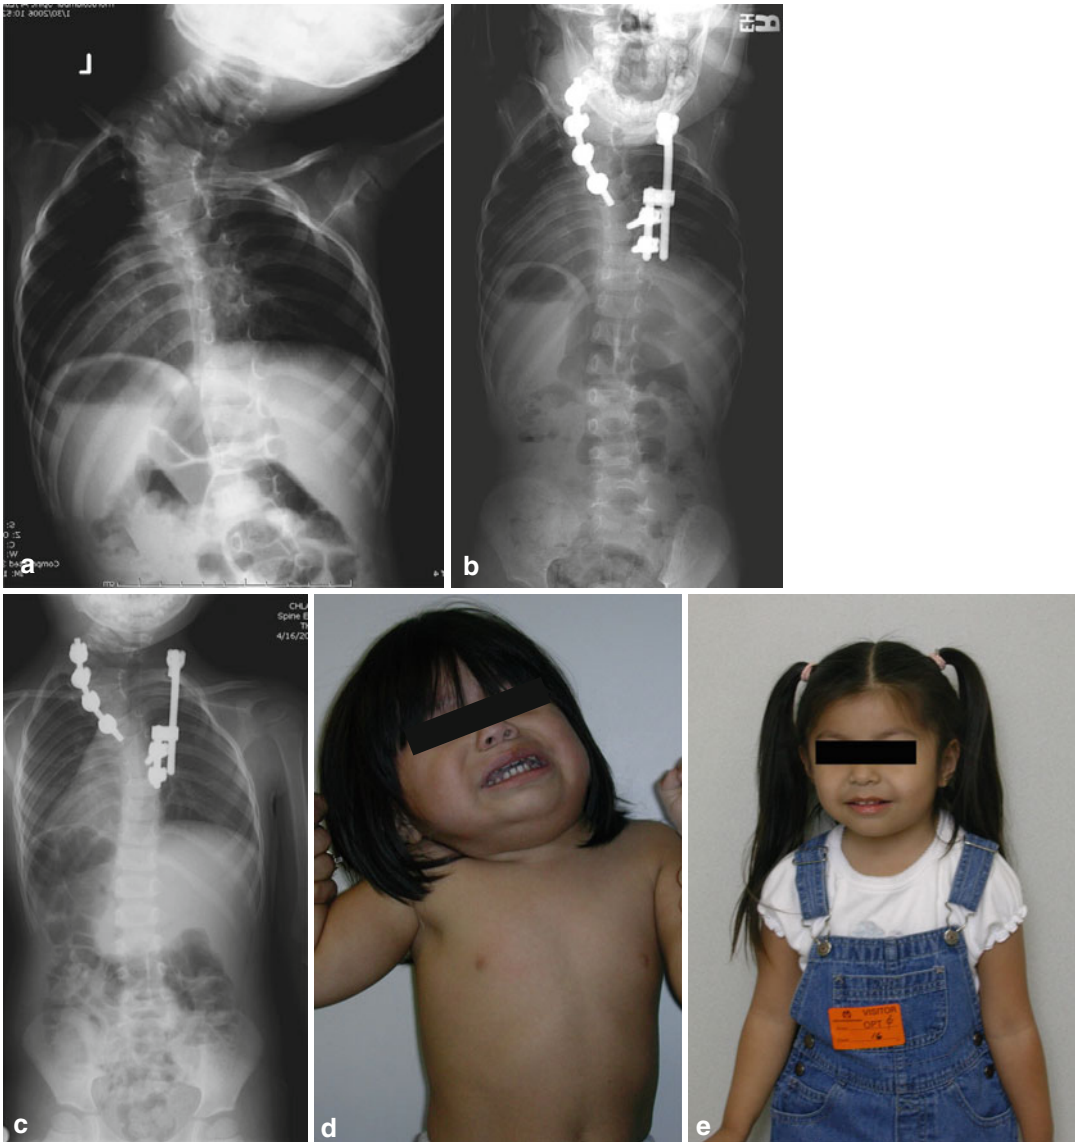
(a) Preoperative AP radiograph demonstrates a unilateral bar opposite six pedicles. (b) Immediate postoperative AP radiograph. Note improvement in head position. (c) AP radiograph 1 year after initial surgery, with one surgical lengthening having been performed in the interim. Note a little migration of the hook on the upper rib, with new rib growing behind it. If this migrates through in the future, the hook could most likely be
